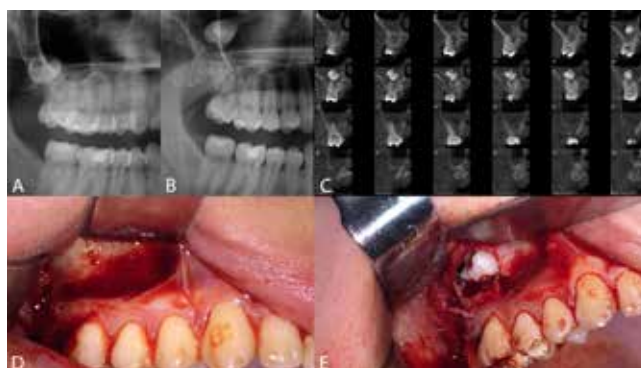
A. Panoramic radiograph before displacement. B. Preoperative radiographs demonstrating migration of tooth in the upper part of the maxillary sinus. C. CBCT image of the displaced tooth. D. Intraoperative view, surgery area. E. The tooth removed from the maxillary sinus during the operation.
